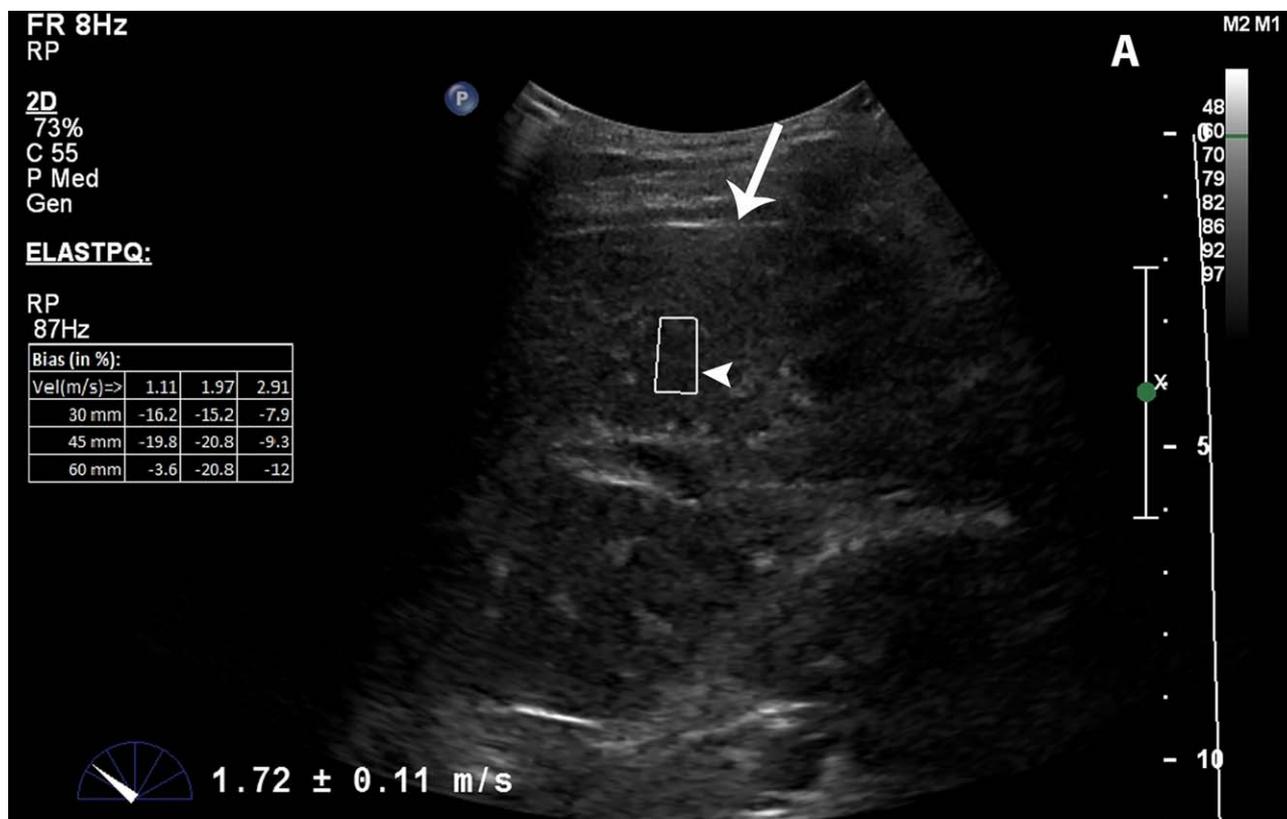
(A) Grayscale ultrasound image with elastography showing the sample box (white arrow) from which the elastography velocities will be calculated. Velocities for that sample are depicted on the table to the left of the image. (B) Report page showing the elastography software calculation of the interquartile ration, average, standard, and median velocities based on the 10 sample measurements obtained
